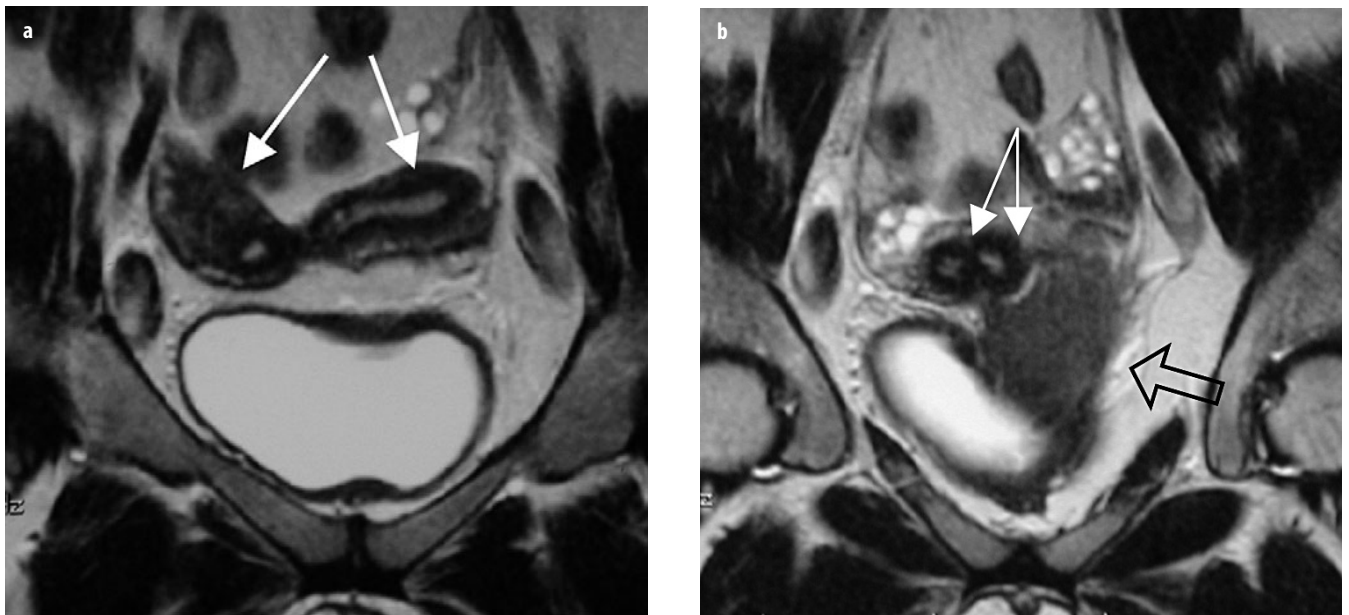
a, b. Müllerian duct anomalies (MDA): uterus didelphys. Coronal T2-weighted magnetic resonance images (MRI) demonstrate: a two divergent uterine horns (*arrows*) and b separate cervixes (*solid arrows*). There is no communication between the paired cavities. A transverse left hemivaginal septum obstructs the ipsilateral vagina, leading to left hemocolpos (*open arrow, b*)
